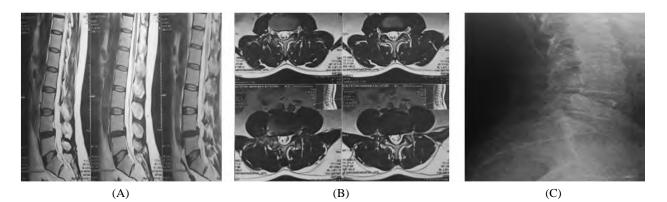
Case (1): MRI lumbar spine sagittal (A) and Axial (B) Views showing L4-5 degenerative spondylolithesis with right para central ruptured disc at level of L 4-5, and preoperative X-ray lateral view (C).
